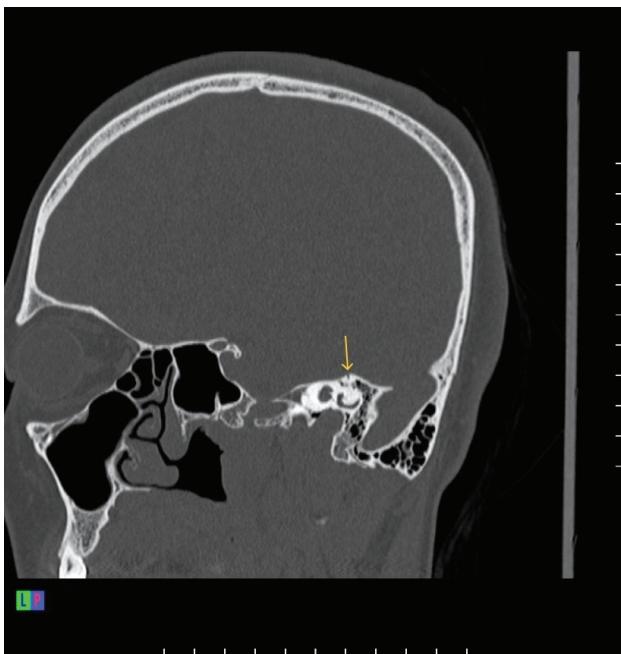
Superior semicircular canal dehiscence in Pöschl view. Coronal CT reconstruction in the Pöschl plane of the same patient reveals a defect in the bony roof of the superior semicircular canal (arrow).
